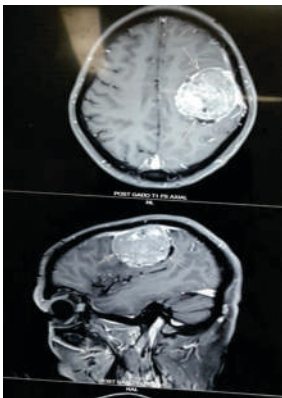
MRI brain showing meningioma:
